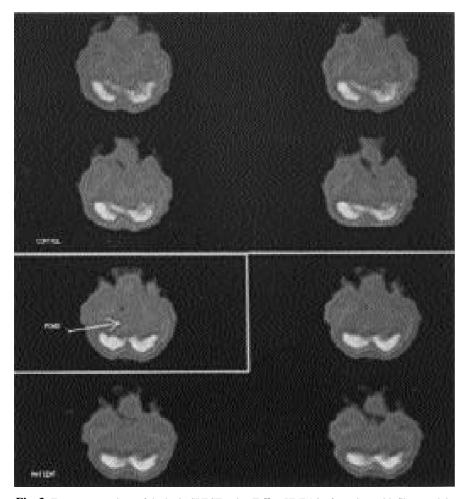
Transverse sections of the brain SPECT, using Tc^{99m} - HMPAO of a patient with fibromyalgia and a normal control. There is a decreased blood flow in the pons in the patient with fibromyalgia comparing with normal subject.
